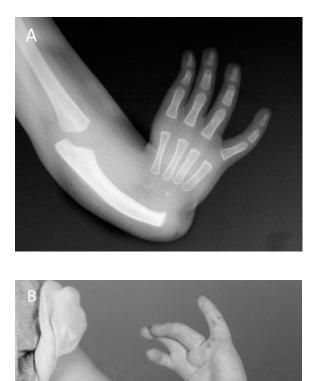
A two-year-old child with complete absence of the radius (Type 4). A) X-ray reveals complete absence of the radius; B) Hand with a perpendicular relationship with the forearm. Source: Shriners Hospital for Children, Philadelphia Unit.
